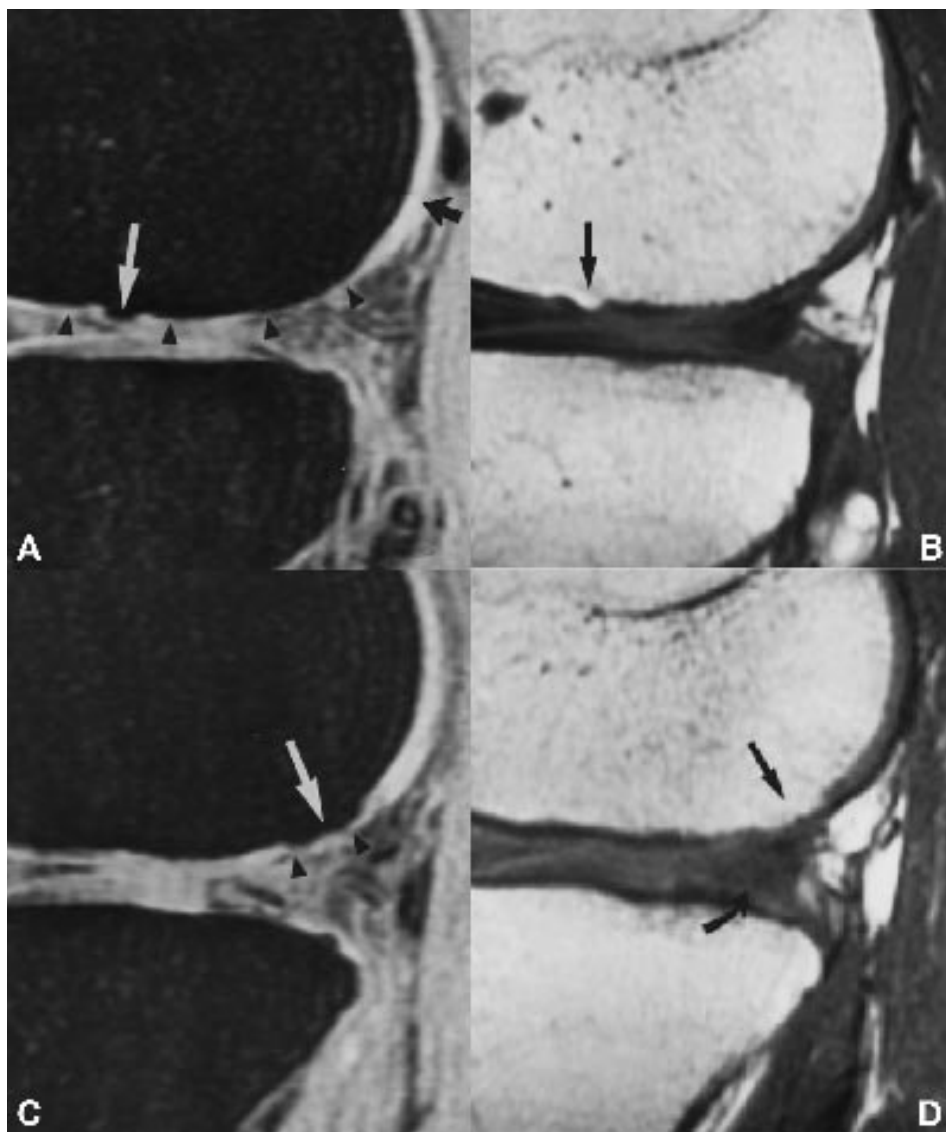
A B C D 46-year-old man with two central osteophytes associated with grade 4 articular cartilage defects. A, Fat-suppressed three-dimensional spoiled gradient-echo MR image (TR/TE, 40/6; flip angle, 40°) shows central osteophyte (white arrow) at lateral femoral condyle incompletely filling base of cartilage defect (arrowheads). Normal articular cartilage, which has high signal intensity on fat-suppressed three-dimensional spoiled gradient-echo MR images, is seen posteriorly (black arrow). B, Sagittal T1-weighted MR image (600/14) obtained at same location as A shows fat signal in central osteophyte (arrow). C, Fat-suppressed three-dimensional spoiled gradient-echo MR image (40/6; flip angle, 40°) shows central osteophyte (arrow) completely filling base of cartilage defect (arrowheads). D, Sagittal T1-weighted MR image (600/14) obtained at same location as A shows fat signal in central osteophyte (straight arrow). Complex tear can be seen in posterior horn of medial meniscus (curved arrow). Note thin layer of high signal intensity covers surface of osteophytes in A and C, and note that both osteophytes involve weight-bearing surface of condyle.
